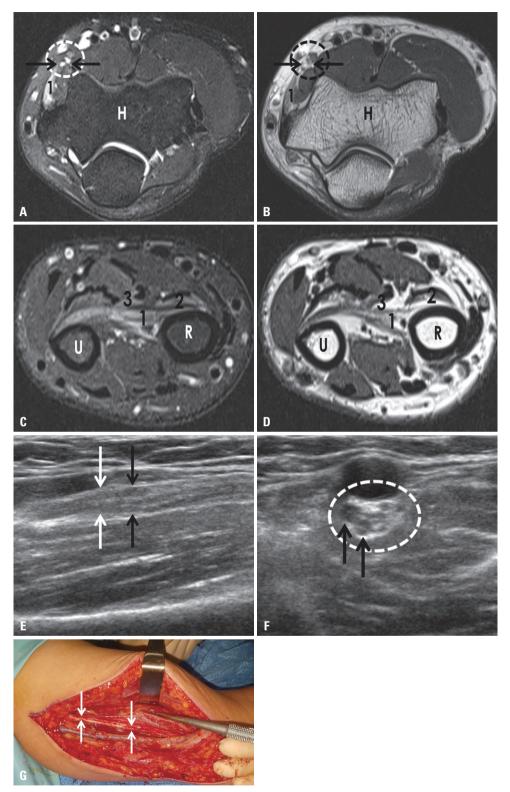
A 45-year-old man with entwinement and constriction of the dorsal fascicle of the left median nerve and pseudo-AIN syndrome. (A and B) Axial FST2-weighted (A) and proton-weighted (B) FSE images of the left elbow show focal swelling (black arrows) in the dorsal fascicle of the median nerve (dotted circle) with high signal intensity in the pronator teres muscle (1). (C and D) Axial FST2-weighted (C) and T1-weighted (D) FSE images of the distal forearm show denervation-related high signal intensities and fatty changes in the pronator quadratus (1), flexor pollicis longus (2), and the radial part of flexor digitorum profundus (3) muscles. (E and F) Longitudinal (E) and axial (F) ultrasonographic images of the distal upper arm show entwinement (white arrows) and mild swelling (black arrows) of the fascicles of the median nerve (dotted circle). (G) During surgery, there were two points of entwinement (white arrows) and a constriction of the AIN fascicle above the elbow. AIN, anterior interosseous nerve; FS, fat-suppressed; FSE, fast spin echo; R, radius; U, ulna; H, humerus.
